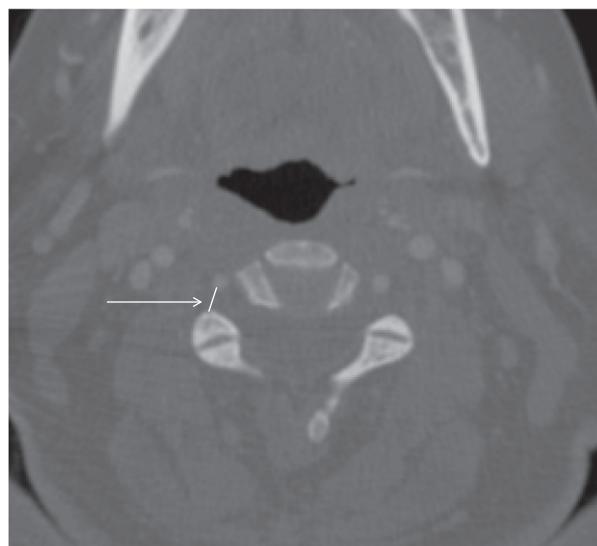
Example of measurement taken from midarticular pillar to vertebral artery on computed tomography angiogram. White arrow pointing to measurement line.
